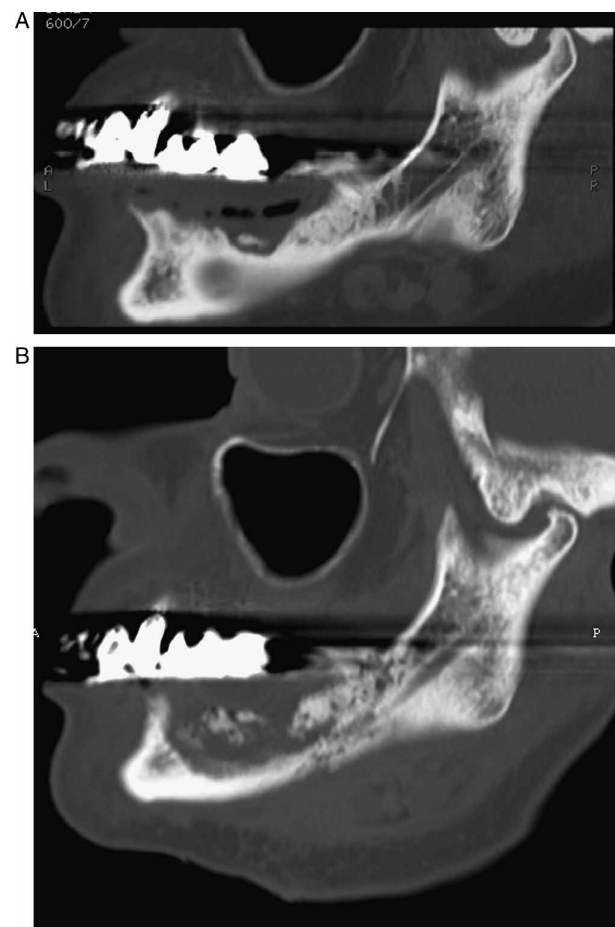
A. ONJ of the right hemi-mandible. First CT oblique sagittal reconstruction displayed with bone window setting showing an osteolytic lesion with a small sequestrum surrounded by sclerotic bone, B. Second CT examination reconstructed in the same plane showing progressive disease characterized by a large area of destruction with small islands of bone or sequestra.
